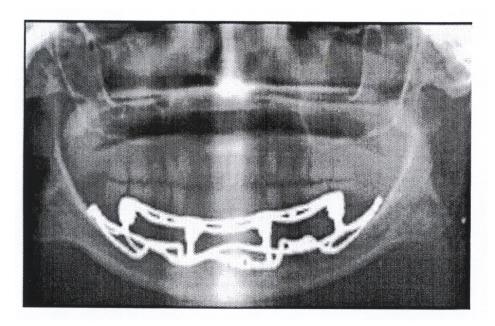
Panoramic radiograph showing subperiosteal implant.
